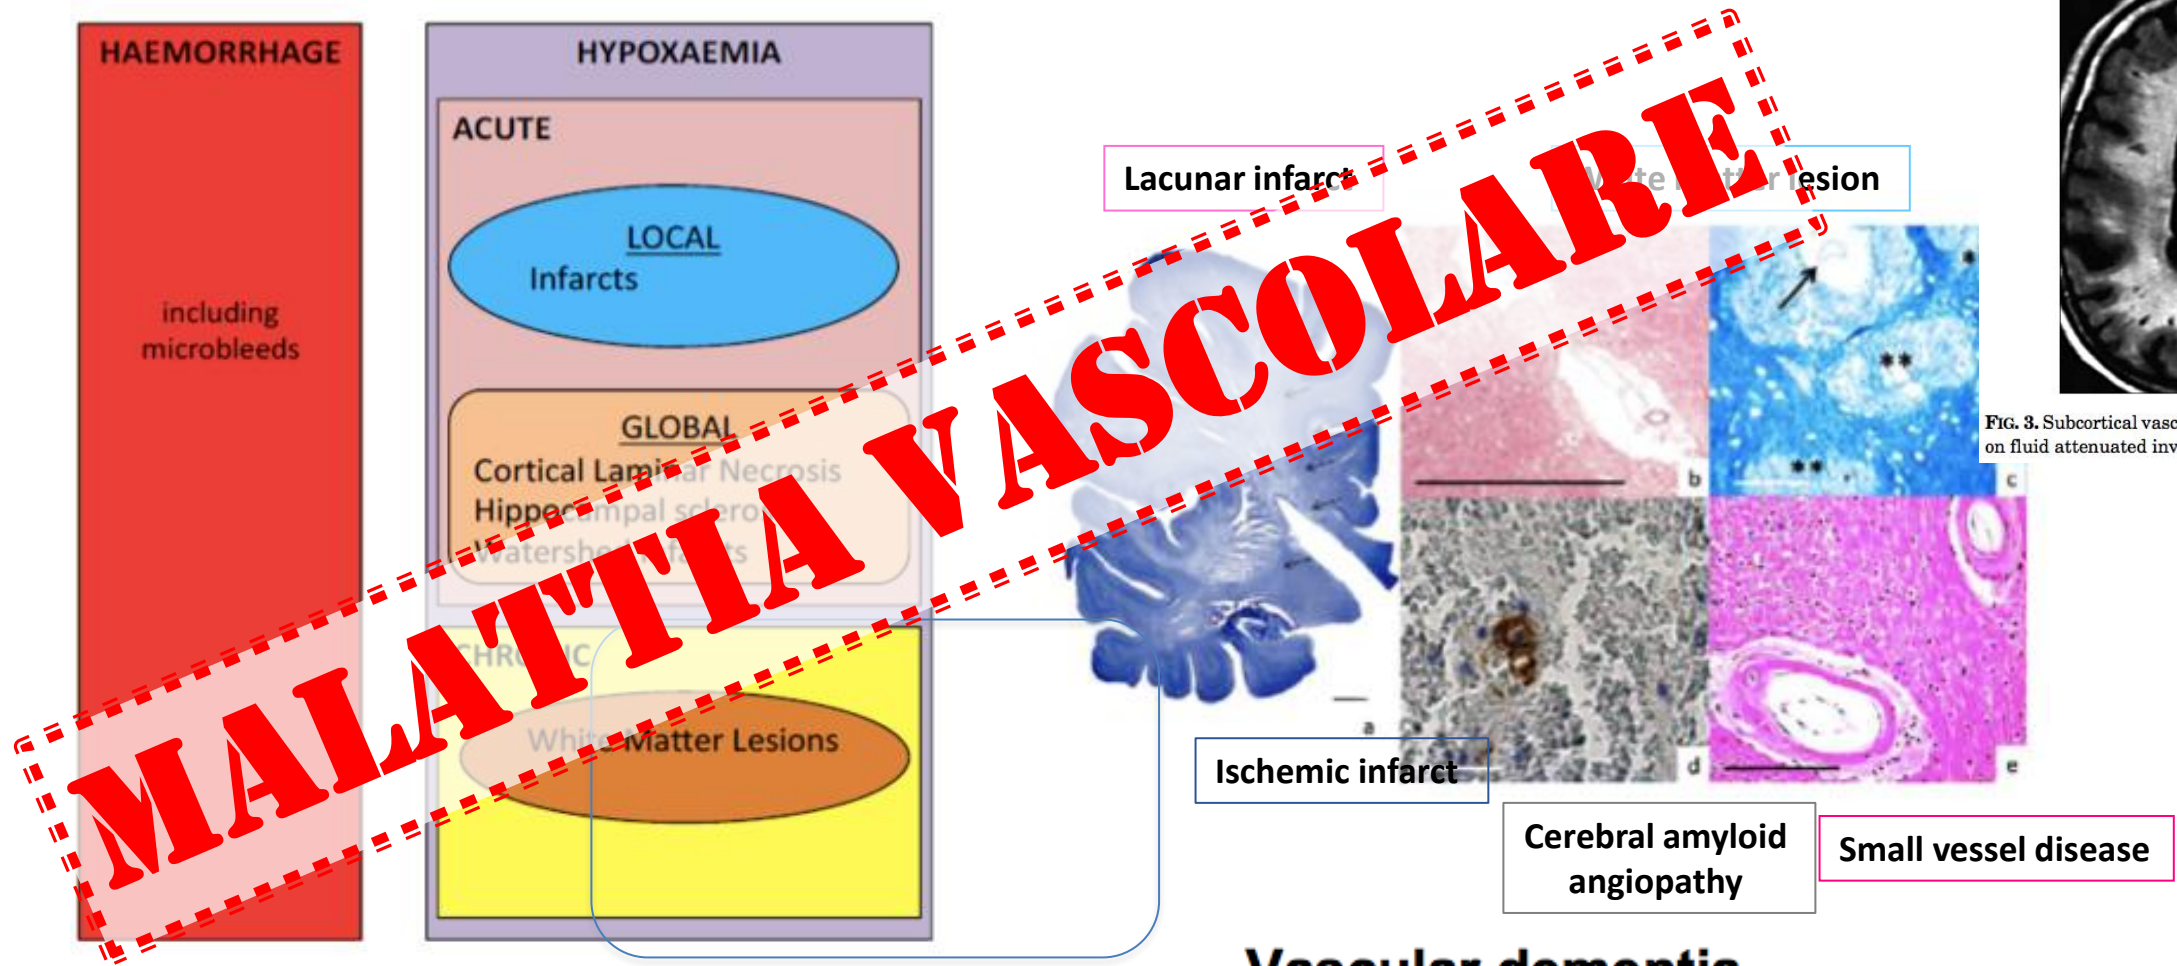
Subcortical vascular dementia type of vascular dementia on fluid attenuated inversion recovery (FLAIR) brain MRI.
